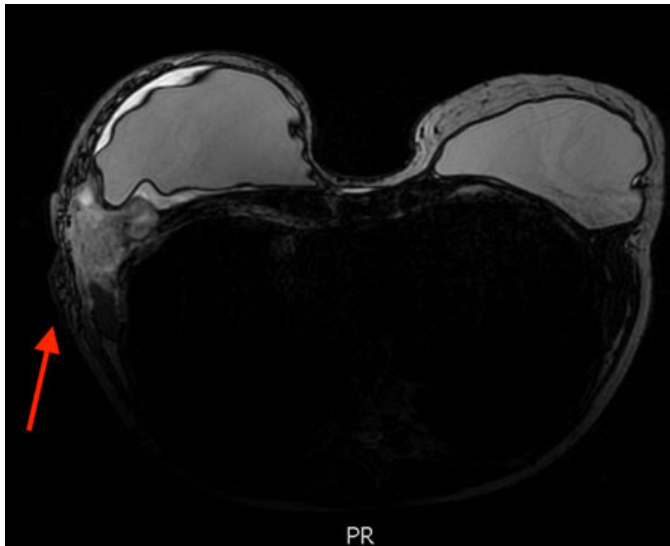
T2-weighted MRI image of bilateral reconstructed breast. Red arrow points to right chest wall lymphoma mass.
